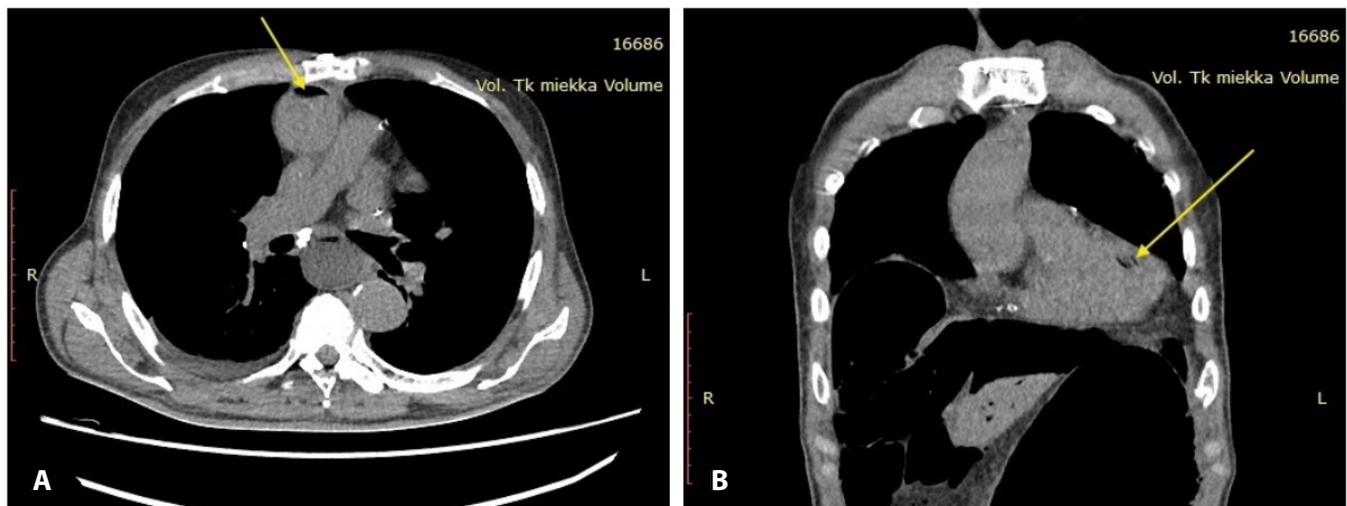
A: Thorax axial CT. Gas in the Aorta (arrow). B: Thorax coronal CT. Gas in the left ventricle (arrow).
